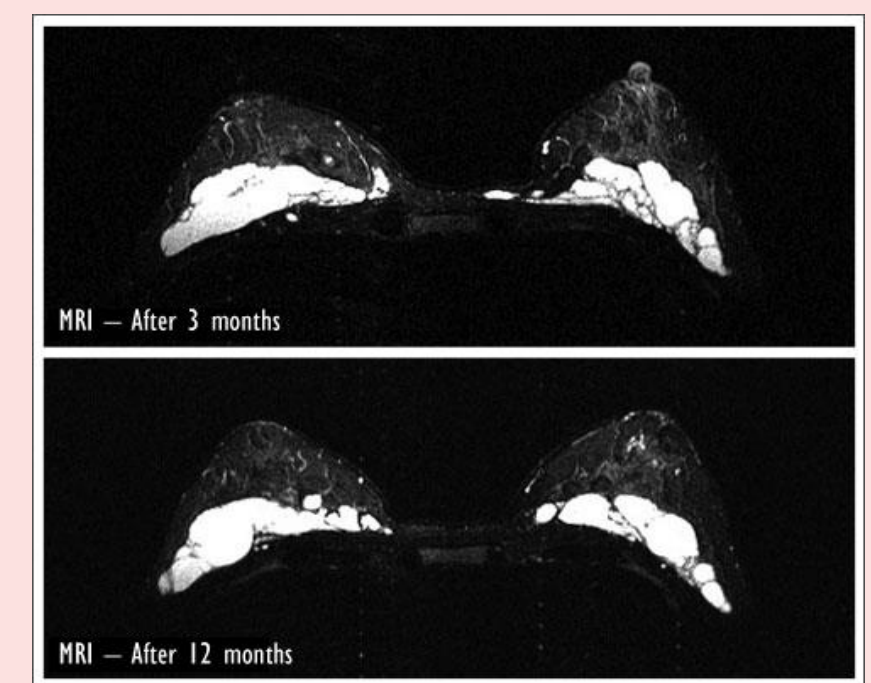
MRI scan 12 months post treatment demonstrates minimal degradation of Macrolane™.
